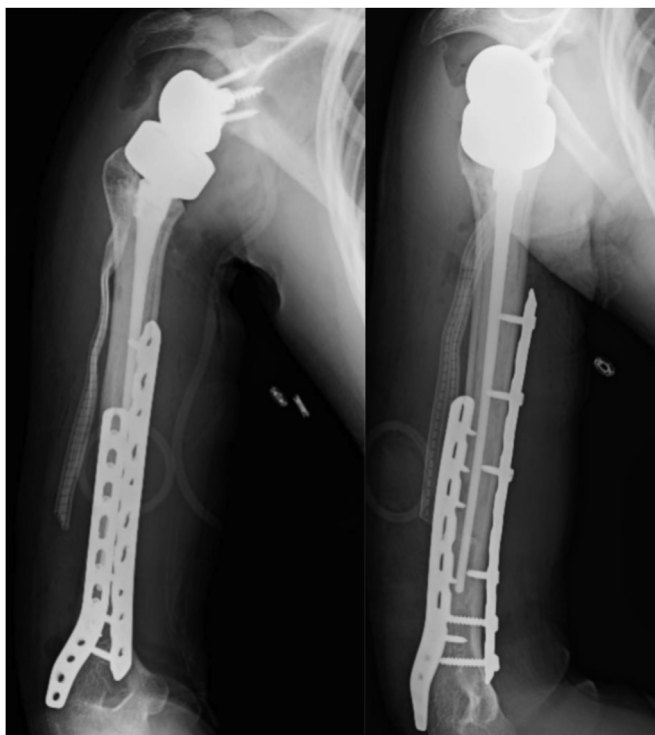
Immediate postoperative radiographs showing the reverse total shoulder arthroplasty and its allograft components.
